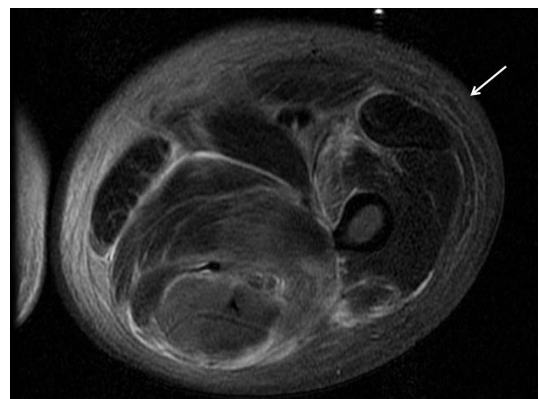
Magnetic resonance imaging (MRI) images of diffuse skin thickening and a reticular pattern seen in the subcutaneous fat extending from the level of the upper thigh to the ankle.
